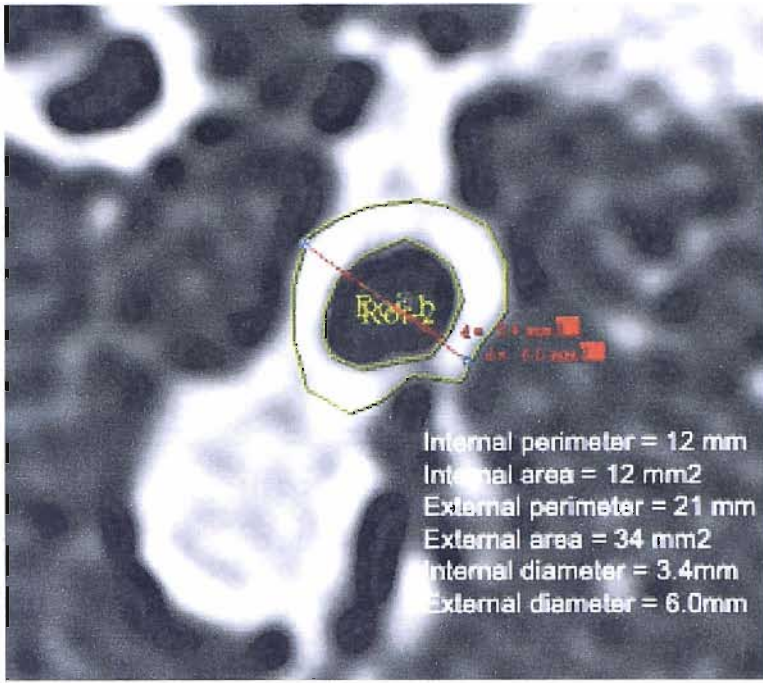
Example of HRCT image analysis using Osiris software.
